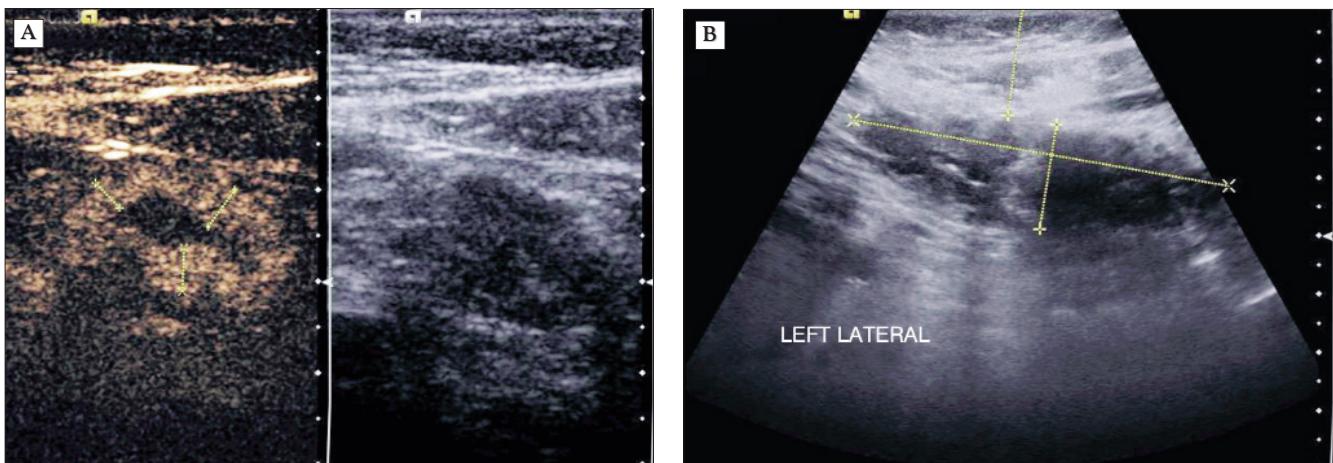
Soft tissue ultrasound – personal collection
